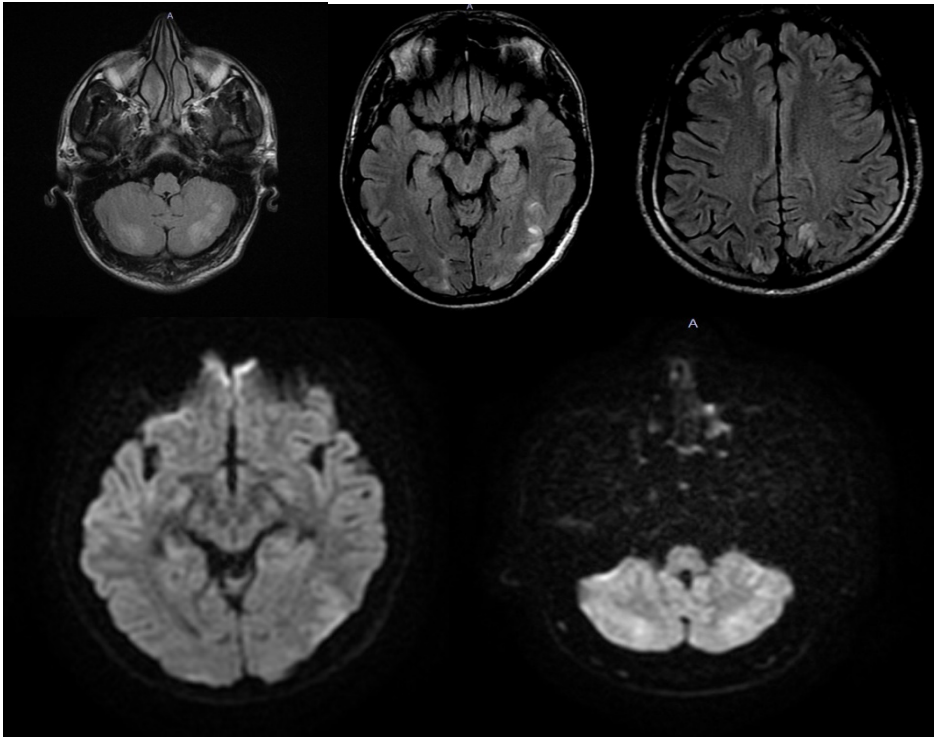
On FLAIR sequences of brain MRI, T2 signal increase was observed in the cerebellum, both cerebellar hemispheres, and the posterior cortex of the brain, and it was consistent with vasogenic edema. Bilateral occipital lobes and posterior parietal lobes showed a similar increase in cortical T2 signal. Diffusion MRI findings were consistent with vasogenic edema
